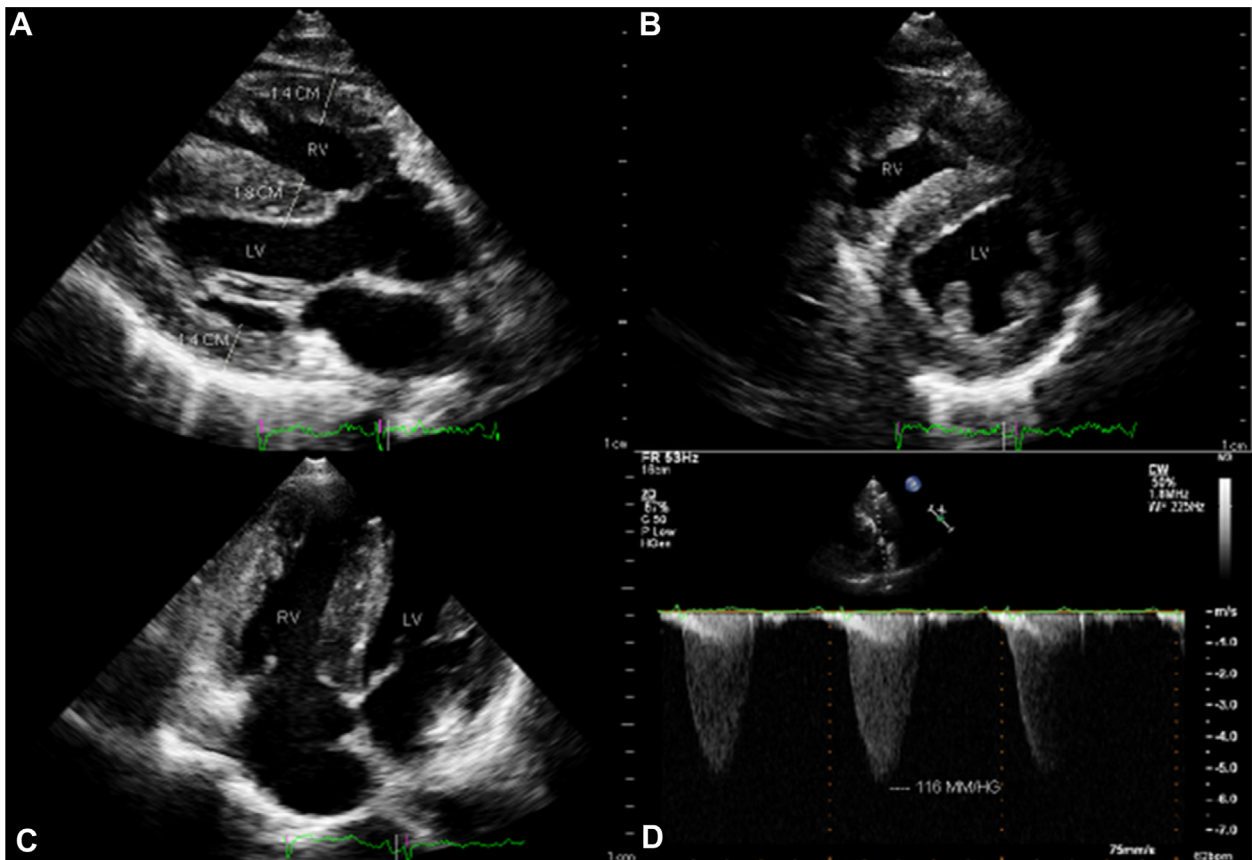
A: Parasternal long axis view biventricular hypertrophy. B: Parasternal short axis view biventricular hypertrophy. C: Apikal four chamber view biventricular hypertrophy. D: Pulmonary artery pulse wave Doppler gradient.
